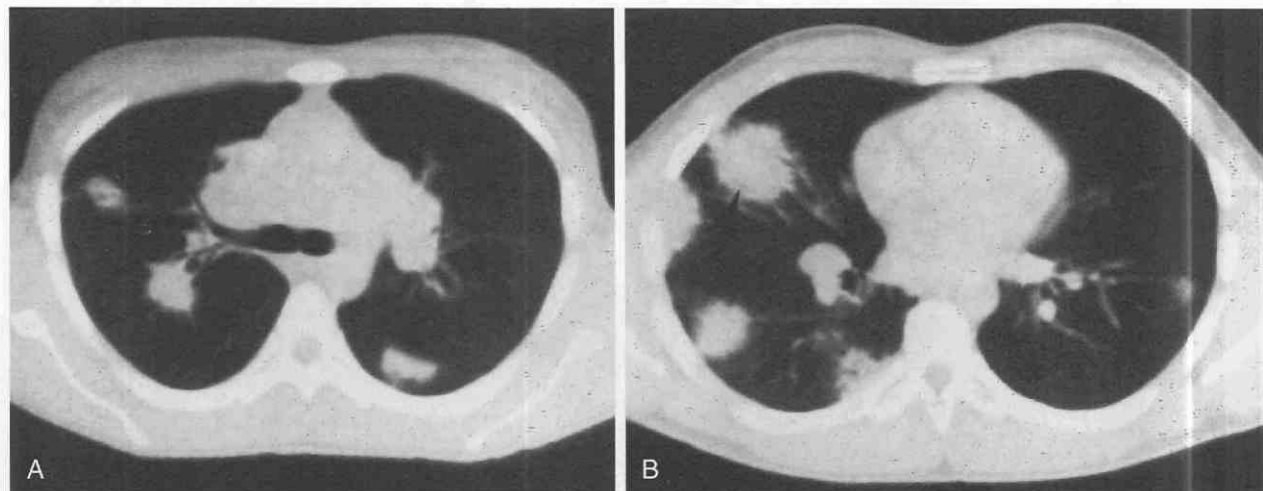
A and B, Alveolar sarcoid. CT shows round masslike consolidations with air-bronchograms. Note hilar adenopathy.
